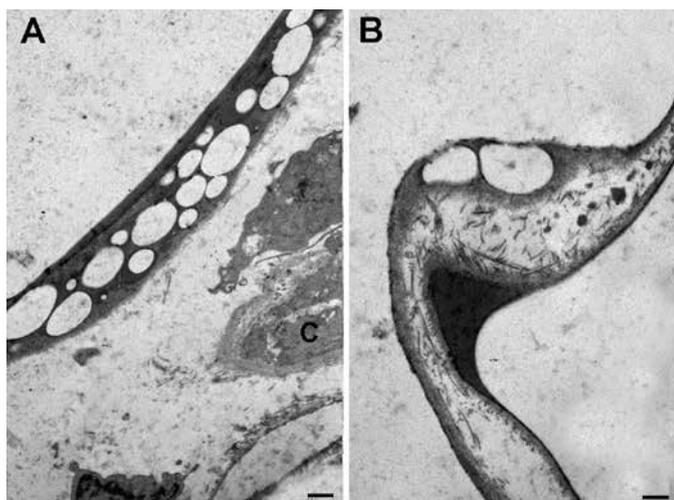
Representative TEM images of adipose tissue from abdominal skin areas subjected to ultrasound pretreatment (1 day) by Med2Contour
